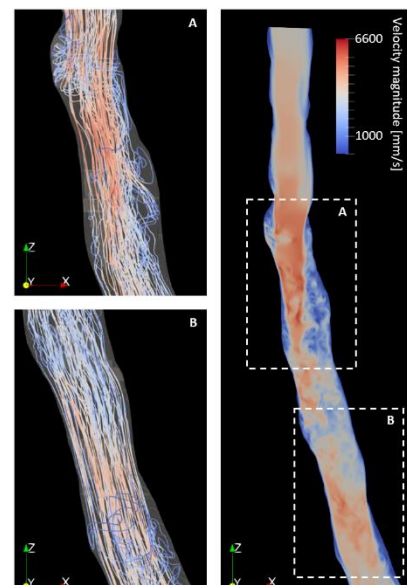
CTA-based CFD showing boundary tripping and flow separation. Velocity magnitude in mm/s.
